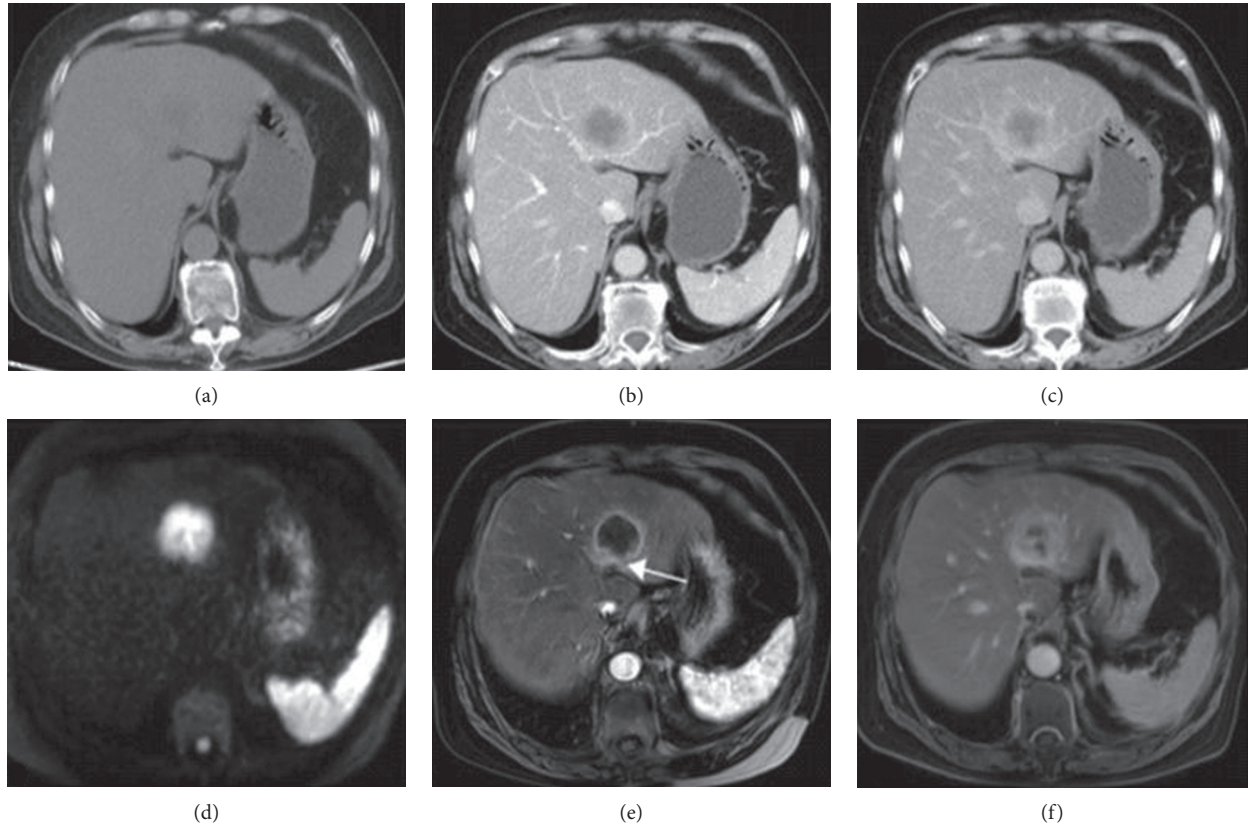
Typical pathological MRI and CT images. In 63 patients with CCA, the lesion was located in the left lobe of the liver. And all patients underwent MRI and CT examinations. (a) CT picture of a typical case, (b) a circular enhancement at the edge of the lesion in the arterial phase, (c) an enhanced inward filling in the equilibrium phase, and (d) DWI picture of the MRI shows high signal intensity. (e) A circular enhancement shows at the edge of the tumor, but the strengthening ring is incomplete. (f) The inward filling of the mass in the equilibrium phase.
